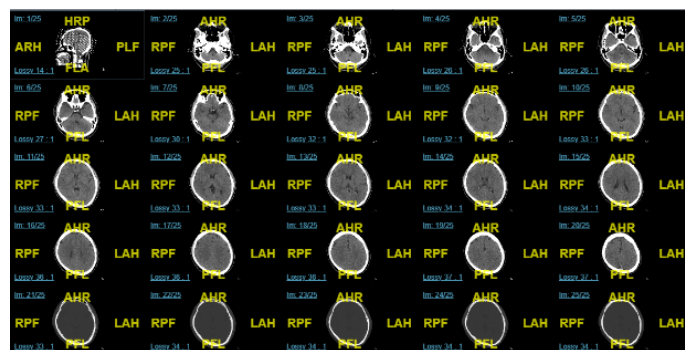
CT-Scan of the Head, within normal limits.
